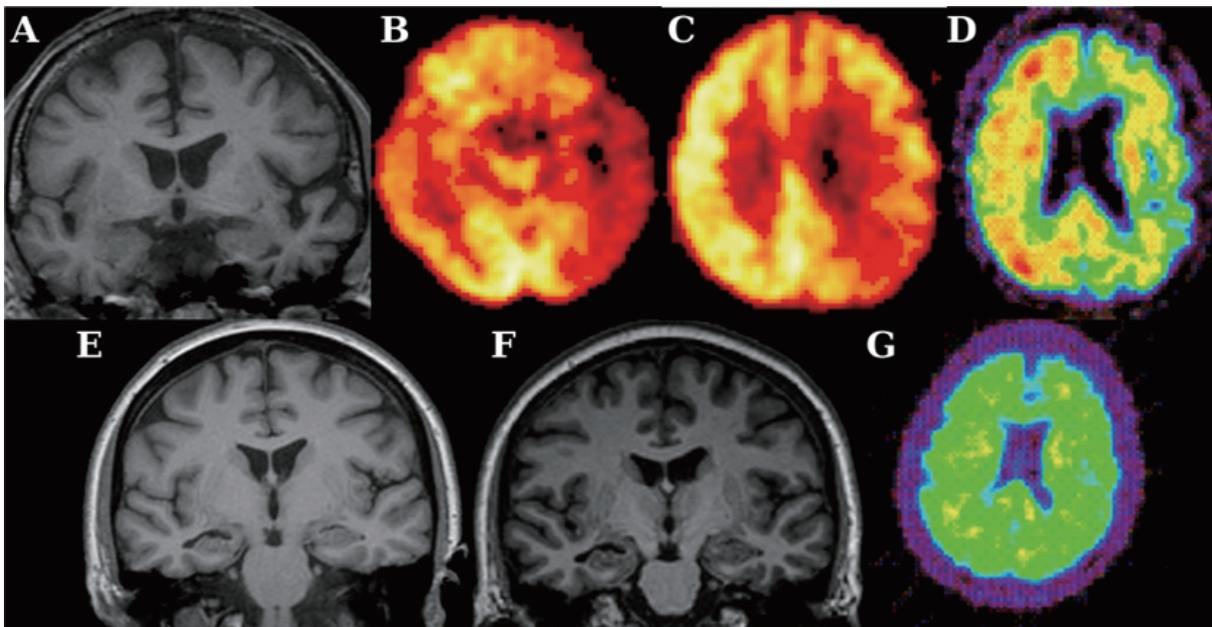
A-D) Patient JD. A) Coronal T1 MRI showing diffuse left temporal lobe atrophy 5 years ago; B) FDG-PET showing left temporal and C) parietal hypometabolism; D) PIB-PET showing cortical amyloid deposition. E-G) Patient KM. E) Coronal T1 MRI showing possible right hippocampal atrophy 4 years before testing. F) MRI at time of current testing, showing lack of change over 4 years. G) PIB-PET (at the same intensity thresholds as panel D) showing absence of cortical amyloid deposition.
